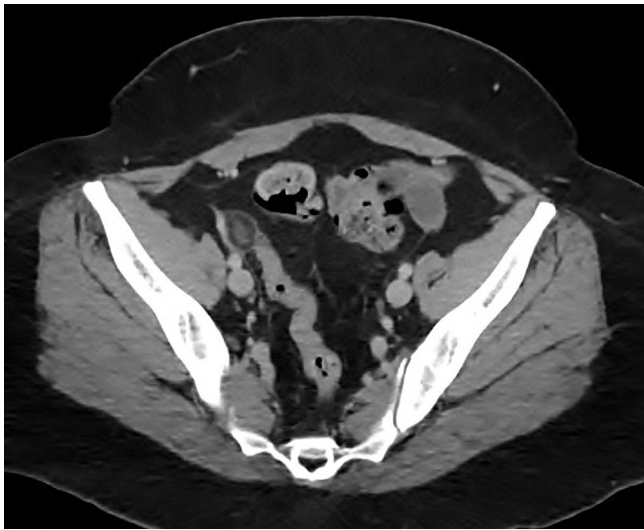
Classic CT scan finding of epiploic appendagitis with a rim-enhancing, oval structure on the exterior of the sigmoid colon located in the right lower abdomen.
